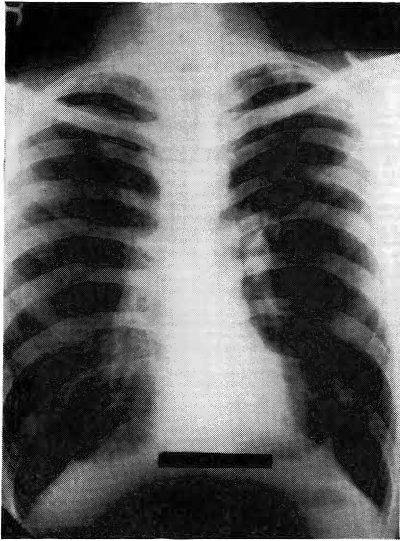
Chest film of a young asthmatic. X-ray alone could lead to a mistaken diagnosis of emphysema.
